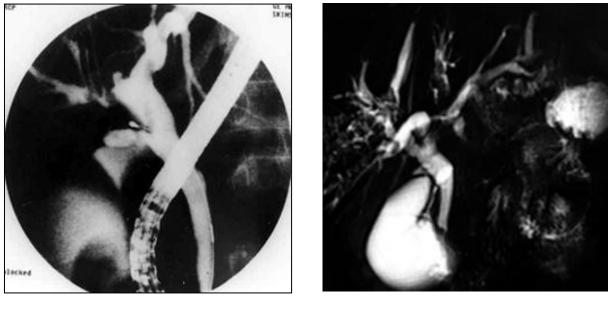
A 45 years old female had 2 episodes of cholangitis with Ultrasound evidence of RPC; she underwent MRCP (A) which shows multiple stones in involving LHD and extensive disease and it's both segments with multiple stones and strictures. After 48 hours of MRCP, patient was hospitalized with pyogenic cholangitis and ERCP (B) revealing stones in CBD, stricture in LHD. Note at MRCP better visualization of major hepatic ducts and branches
